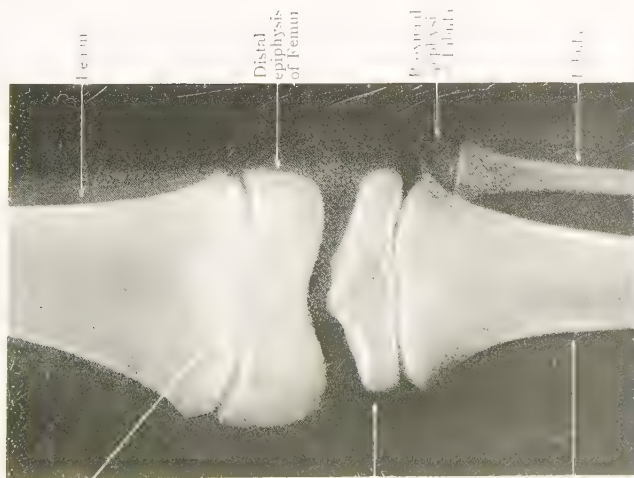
Anteroposterior Radiograph of slightly flexed
